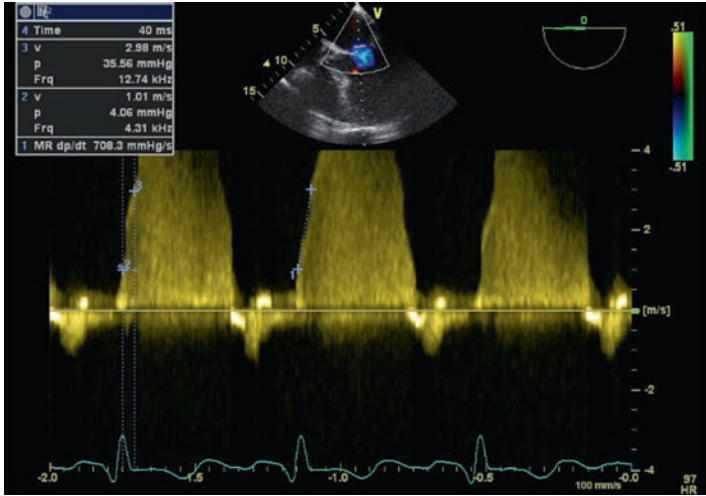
Continuous wave Doppler recording of a mitral regurgitant jet with the dp/dt measured using online software (measurement 1) and manually (measurements 2, 3, and 4).
